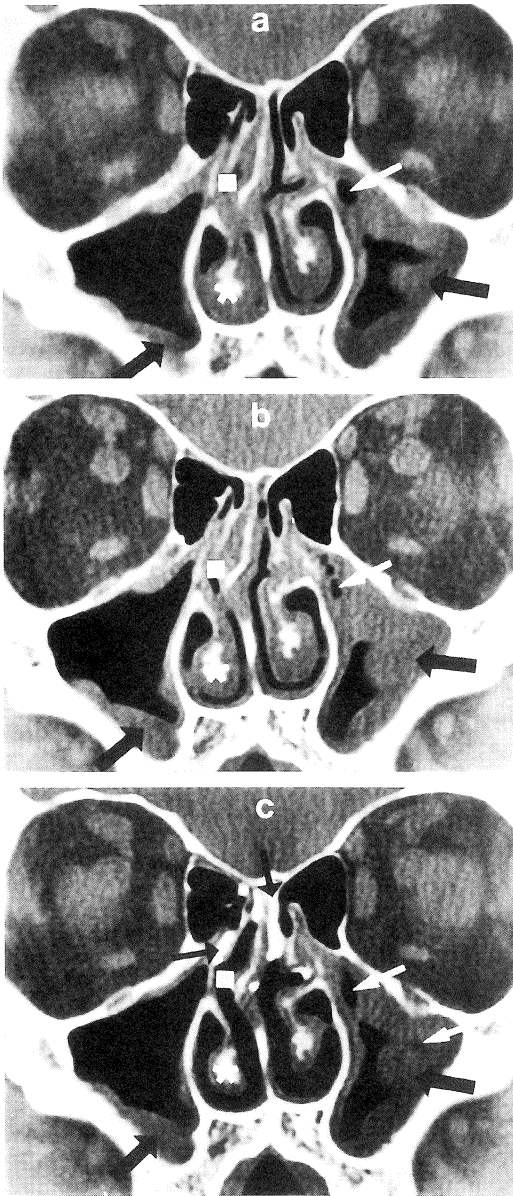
Serial sinus CT scans of an adult with a common cold of 4 days' duration. The first scan (*a*) was obtained at 2:00 p.m. There are abnormalities in both maxillary sinuses (*black arrows*). A gaseous bubble is present on the left (*white arrow*), indicating that the material causing the abnormality is thick fluid. The nasal turbinates are engorged (*asterisk*), and the middle meatus is congested (*square*). Immediately after the scan was obtained, the patient was given 60 mg of pseudoephedrine orally. The second scan (*b*) was obtained at 4:00 p.m. on the same day. The material in the maxillary sinuses (*black arrows*) has not moved, and the findings are essentially unchanged after treatment with pseudoephedrine. The turbinates remain engorged (*asterisk*) and the middle meatus congested (*square*). Immediately after the scan was obtained, the patient was given two intranasal sprays of .05% oxymetazoline. The third scan (*c*), obtained 10 minutes after oxymetazoline administration, shows shrinkage of the turbinates (*asterisk*) and decongestion of the middle meatus (*square*). Omnipaque dye was given intranasally immediately before the scanning while the patient was supine and is present in the middle meatus and olfactory recess (*small black arrows*). The location of the material in the maxillary sinus cavities (*large black arrows*) has not changed.
